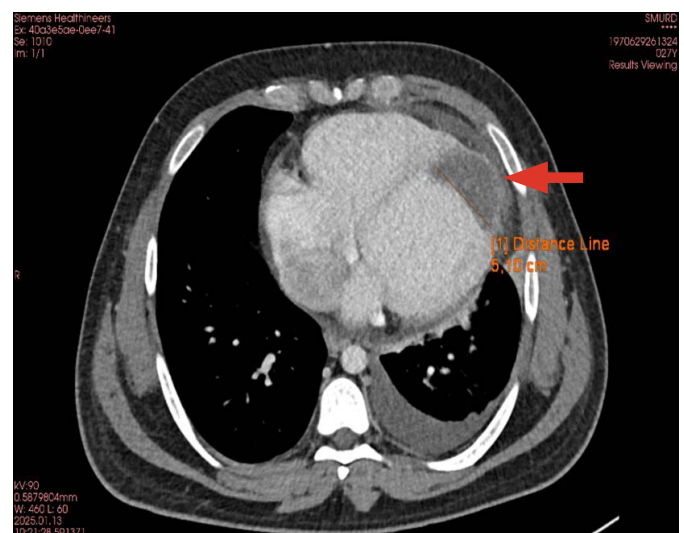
Cardiac computed tomography imaging showing a large thrombus at the left ventricular apex (arrow).
